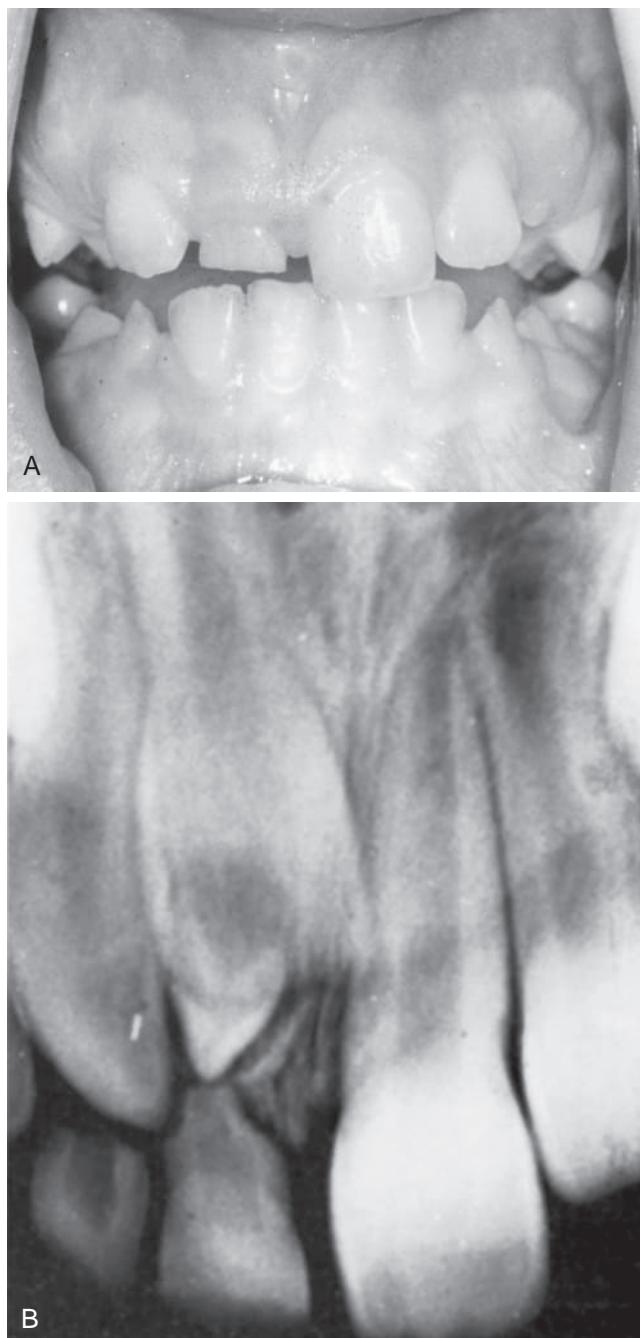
(A) Patient with an unerupted maxillary permanent central incisor and retained primary central incisor. Permanent laterals are erupting. (B) Radiograph shows a supernumerary tooth (mesiodens), which has delayed the eruption of the permanent incisor.
